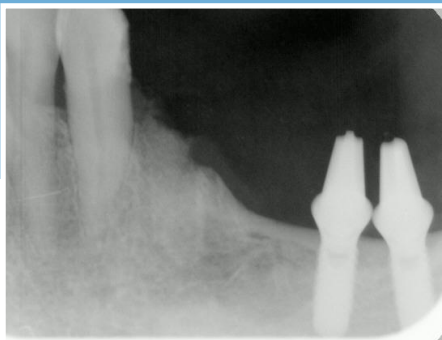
Radiographic appearance of the graft at three months: the radio-opacity of the grafted area is not significantly different from that of the surrounding bone tissue.
